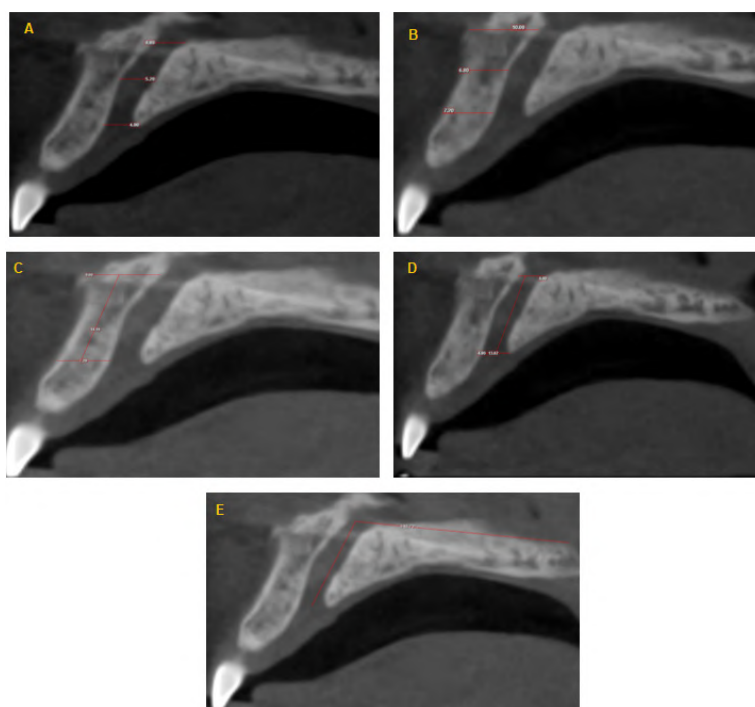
CBCT Images of NPC dimensionality in Sagittal section (A = Transverse diameter at 3 levels, B = Labial Bone Width, C = Labial Bone Length, D = NPC length, E = Angulation of NPC to the hard palate).
